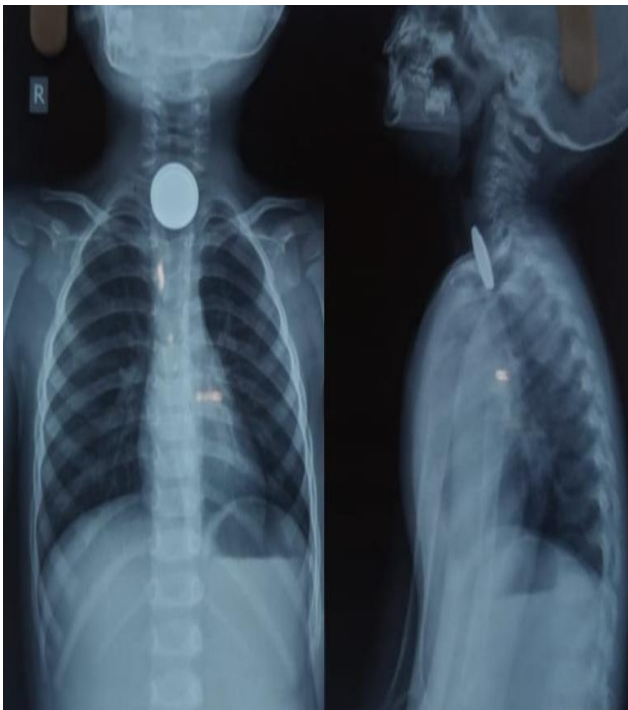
Radiograph of chest in anteroposterior single coin shadow and lateral view of soft tissue neck showing double shadows of foreign body coins.
